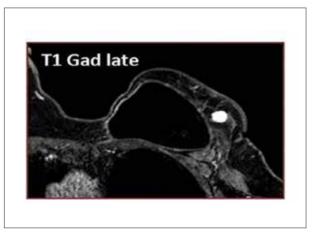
Magnetic resonance shows a well circumscribed nodule of 12 mm on the left reconstructed breast, anterior and lateral to the prosthesis, which corresponded to a second recurrence. The lesion exhibited an early pronounced and persistent enhancement, profiling a type 2 curve. The nodule showed restriction on DWI studies (b1000), but the corresponding ADC value was high (1.6).
